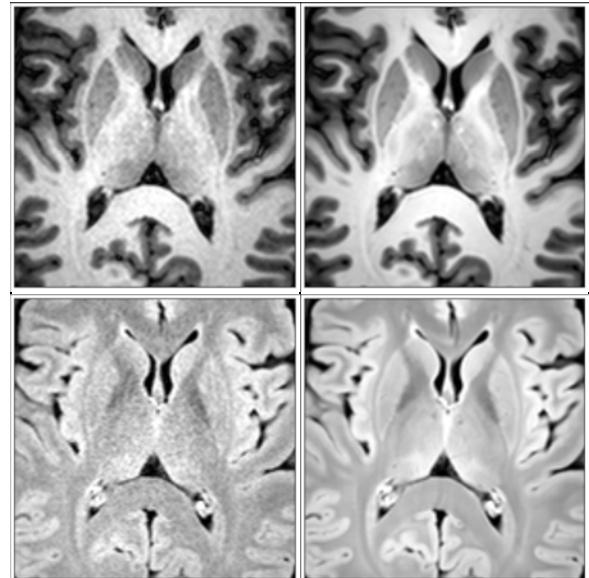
First MPRAGE (top left), mean MPRAGE of the 162 scans (top right), first FLAIR (bottom left), and mean FLAIR of the 162 scans (bottom right).
